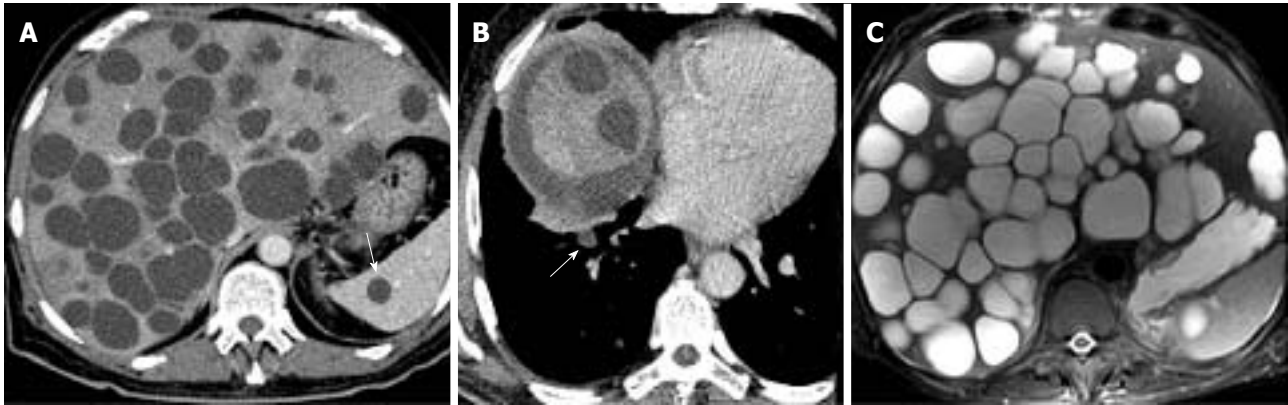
A: Abdominal computed tomography scan shows multiple cyst lesions in the liver and one cyst in the spleen (arrow); B: Axial scanning plane of the lung base shows a small cystic lesion in the right side (arrow); and C: magnetic resonance imaging of the liver with axial T2 weighted image shows homogeneous fluid signal intensity masses related to the cystic nature of hepatic lesions.
